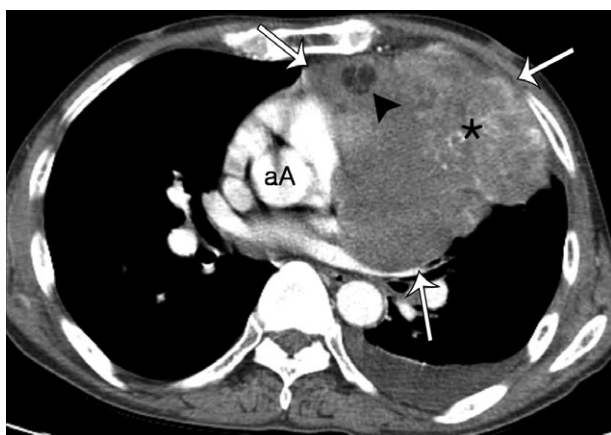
Follow-up contrast-enhanced computed tomography (CT) imaging at three months. The anterior mediastinal mass (arrows) also shows marked interval growth and heterogeneous enhancement with a marked hypervascular portion (asterisk). Also the fat component within the tumor (arrowhead), which was not clear on baseline CT, is clearly demonstrated.
